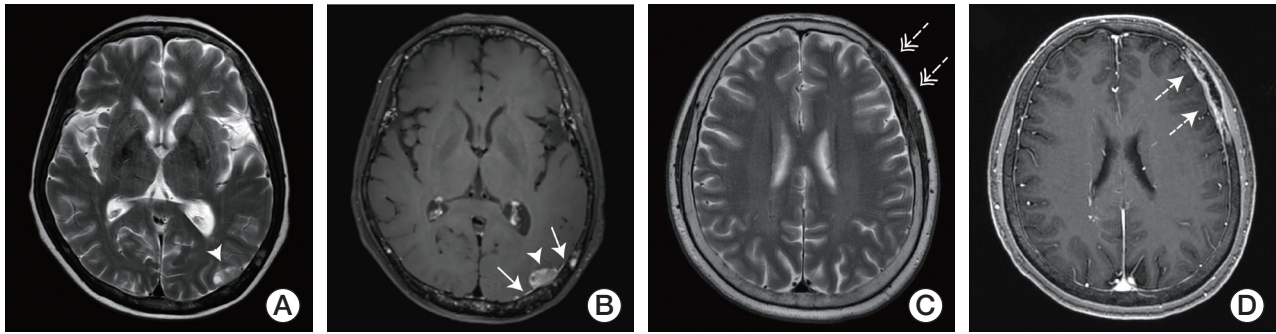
Representative cases of nodular (A, B) and diffuse types of dural metastasis (C, D). (A) Nodular type of dural metastasis in left occipito-temporal region on T2-weighted image (T2WI) (arrowhead). (B) Dural tail was noted on contrast enhanced T1-weighted image (CE-T1WI) (arrows) accompanied by nodular dural metastasis (arrowhead). (C) Bone metastasis in left frontal bone on T2WI (double arrows). (D) Diffuse type of dural metastasis observed on CE-T1WI (dotted arrows).
